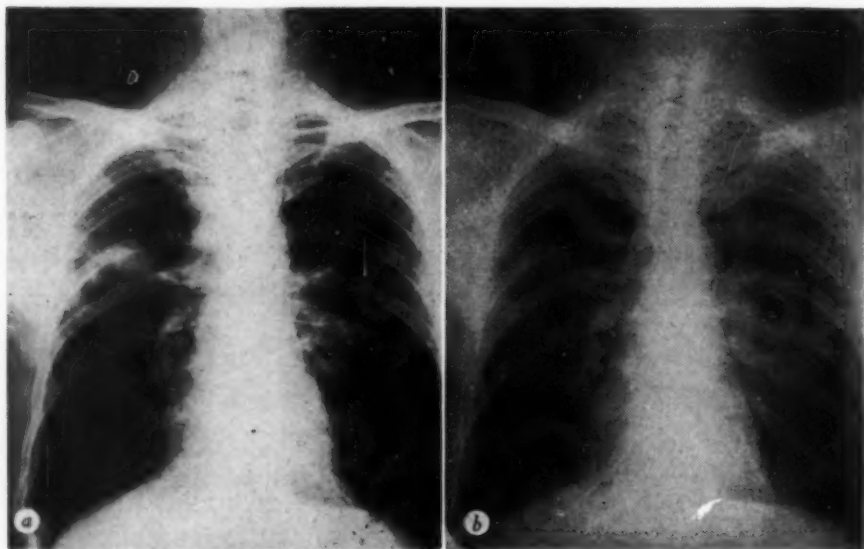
Roentgenograms of the chest in case 2.
